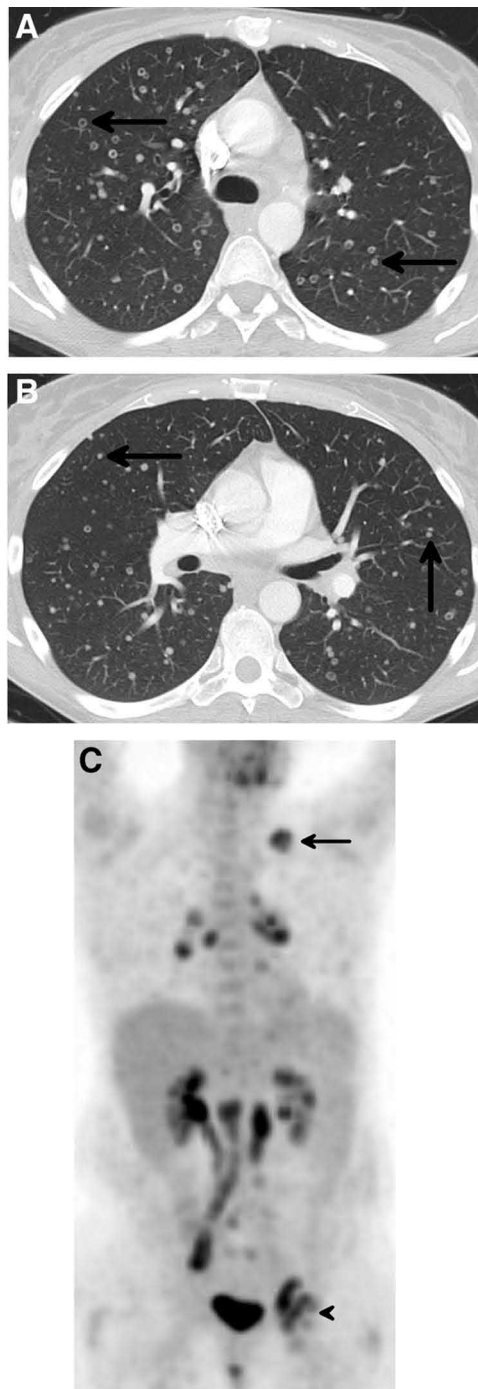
Axial computed tomography (CT) chest (lung window) demonstrating multiple bilateral solid and cavitating pulmonary metastases (arrows) at (A) carinal and (B) subcarinal levels. C, Restaging Positron Emission Tomography (PET) image confirming metastatic activity with intense F-18 Fluorodeoxyglucose (FDG) uptake in bilateral iliac, left inguinal (arrowhead), left pelvic wall, para-aortic and retro-crural regions as well as within the lungs and Virchow node (arrow).
